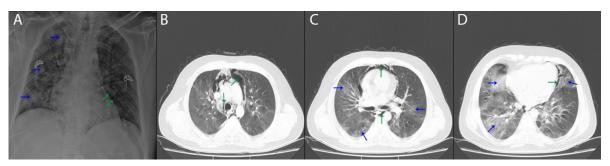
Radiological findings of Case 2. The posteroanterior chest radiograph (A) showed consolidations (blue arrow), and PM (green arrow). An axial (B, C and D) chest CT scans revealed diffuse PM (green arrow), bilateral diffuse areas of ground-glass opacity, and consolidations (blue arrow).
